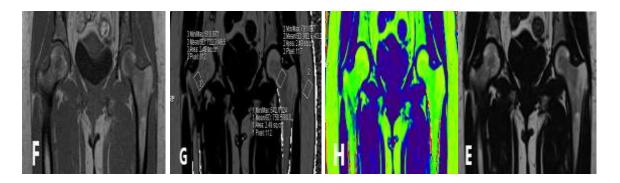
T2DM patient (A, B, C, D) Sagittal lumbosacral spine Dixon MRI fat only image, add (fat + water), divide image (FF = FO/FO+WO) and colored fat fraction map respectively showing increased FF measuring about 70%. (E, F, G, H) Coronal both hips Dixon MRI fat only image, add image (fat + water), divide image (FF = FO/FO+WO) and colored fat fraction map respectively showing increased FF measuring about 82%.
